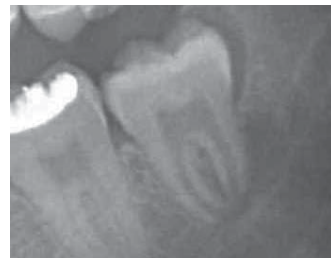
Pathology associated with semi-impacted mandibular third molars: Radiograph of periodontal pocket at the distal aspect of mandibular third molar.
